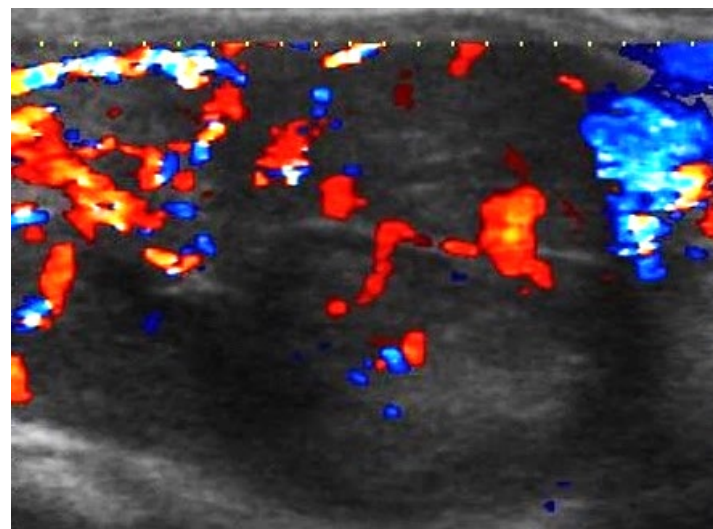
Same lesion exhibits disorganized, predominantly central Doppler flow.
